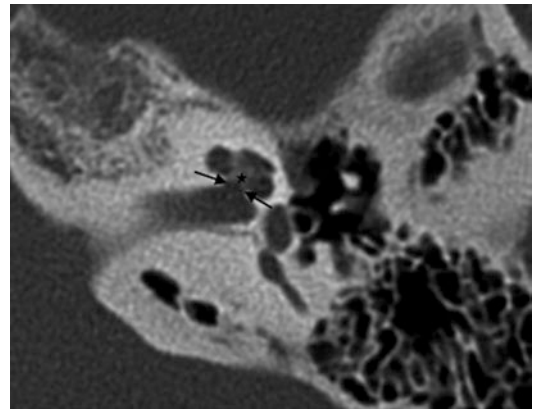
CT anatomy of the cochlea. Axial temporal bone CT image demonstrates normal appearance of the cochlear aperture (delineated by the arrows). Note the normal appearance of the Modiolus (star) at the base of the cochlea
